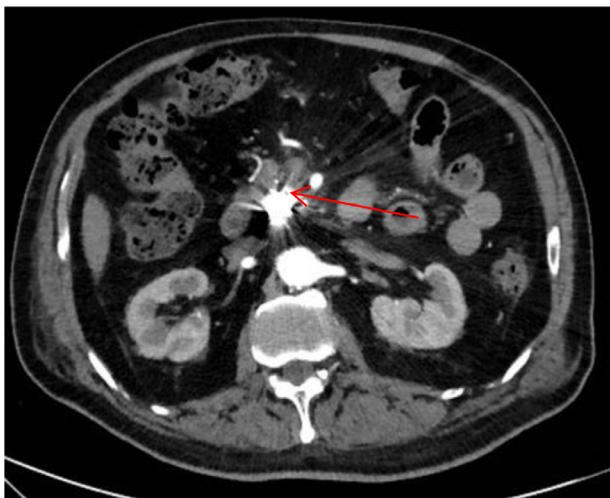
Axial contrast enhancement CT. No evidence of the pseudoaneurysm in the pancreatic region (arrow).
